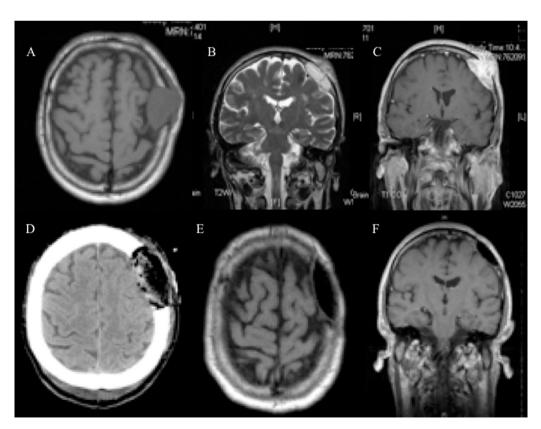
(A–C) Pre-operative MRI imaging revealed a large extra-axial lesion with epicenter in left frontal bone and intradural invasion, predominantly isointense on axial T1-weighted image (A), hyperintense on coronal T2 weighted image (B) and with contrast enhancement (C). (D) Postoperative CT scan showed a good restoration of the cranial deformity. (E, F) Follow-up MRI axial and coronal T1 weighted images with Gadolinium demonstrated no evidence of recurrence.
